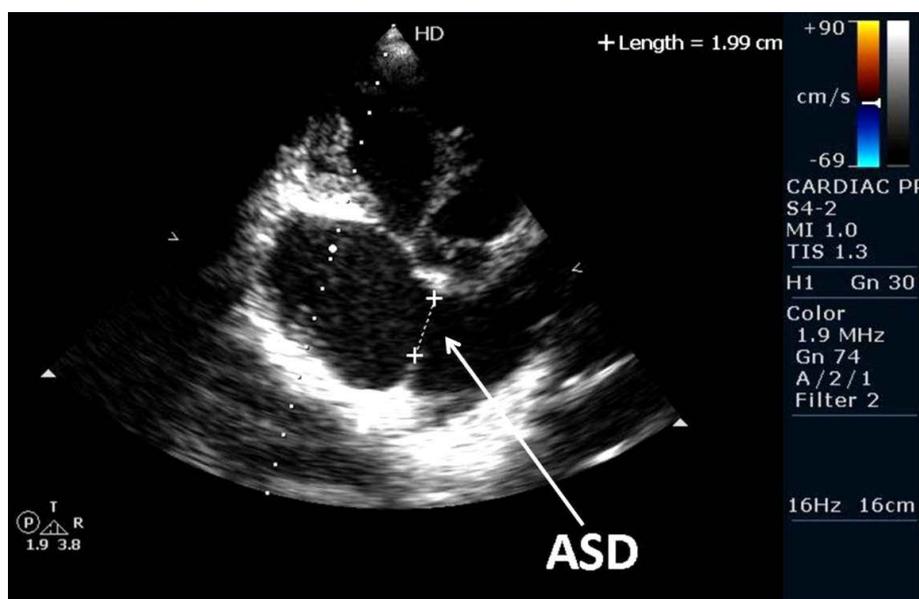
Transesophageal echocardiography confirmed the diagnosis of ostium secundum atrial septal defect.
